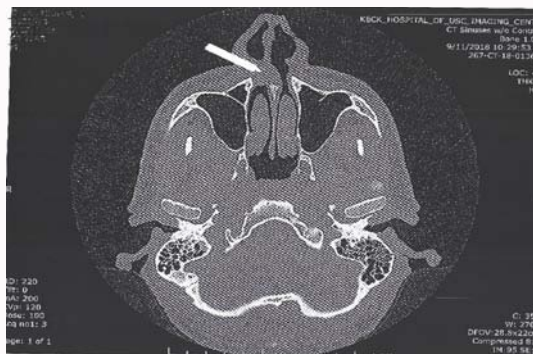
CT scan showing right nasal mass near the head of the inferior turbinate.
